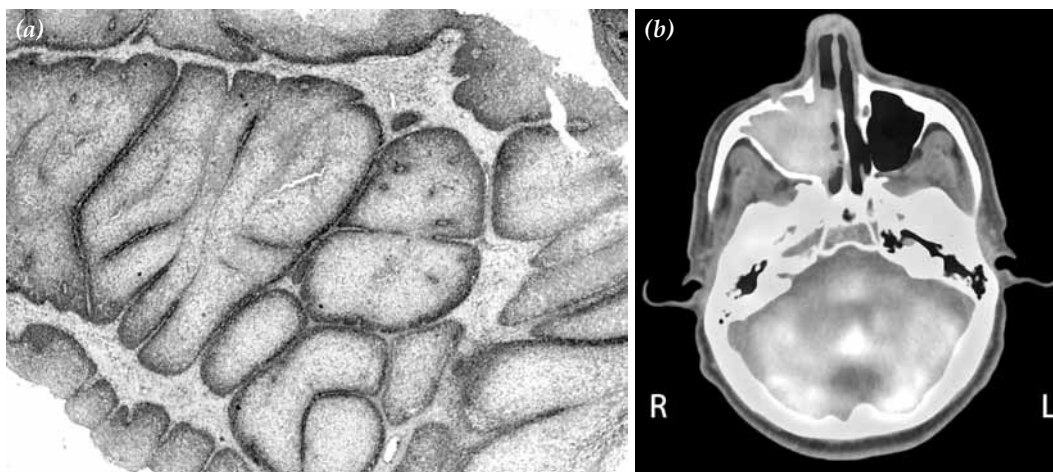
In inverted papilloma, (a) hyperplastic epithelial islets (H-E x 200). (b) Positron emission tomography/computed tomography image of the same patient.
